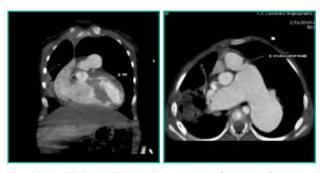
CT Scan Heart: Suggestive of ventricular septal defect, hypertrophy right ventricular wall with infundibular stenosis.
